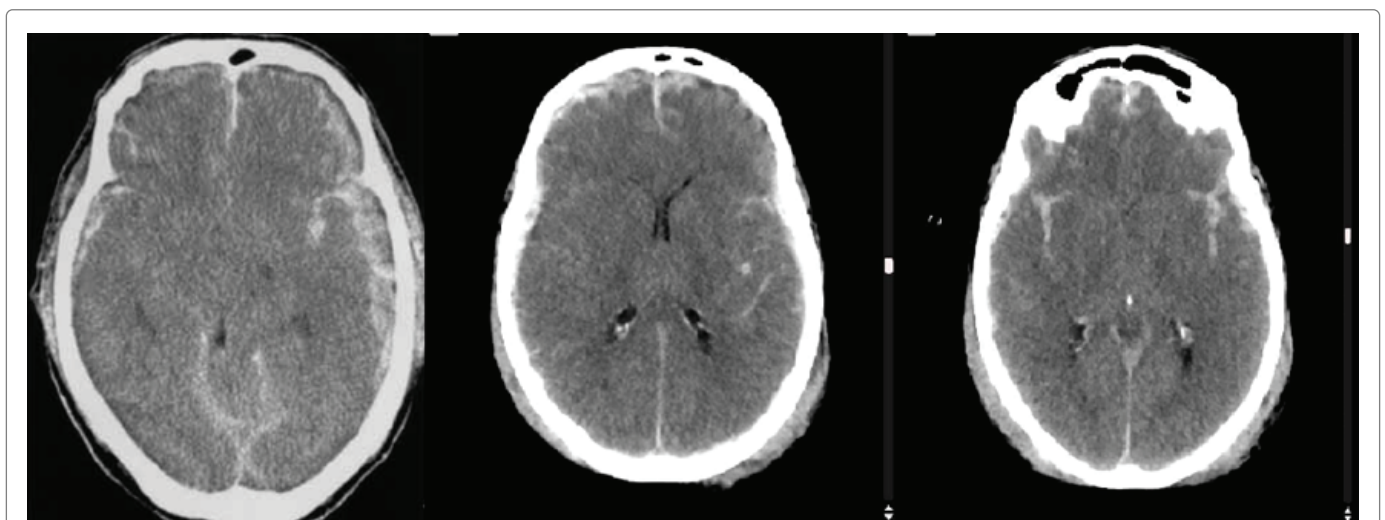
Cerebral CT scan demonstrating general cranial edema with blurring of the cortico-subcortical junction and shrinkage of the cerebral ventricles.
